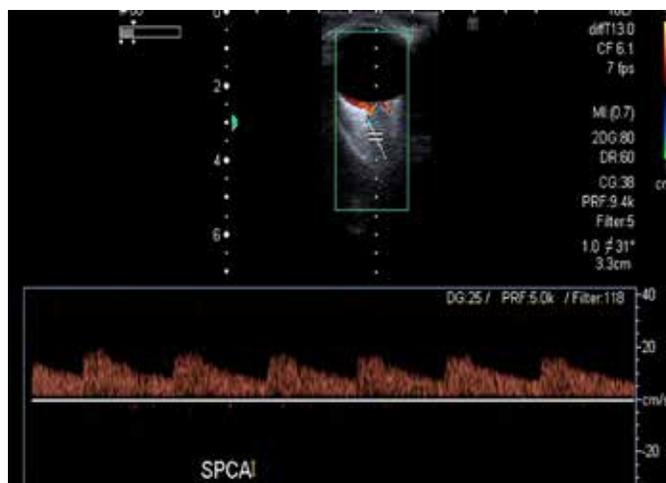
Color doppler image of vessel and corresponding waveform of posterior ciliary artery
